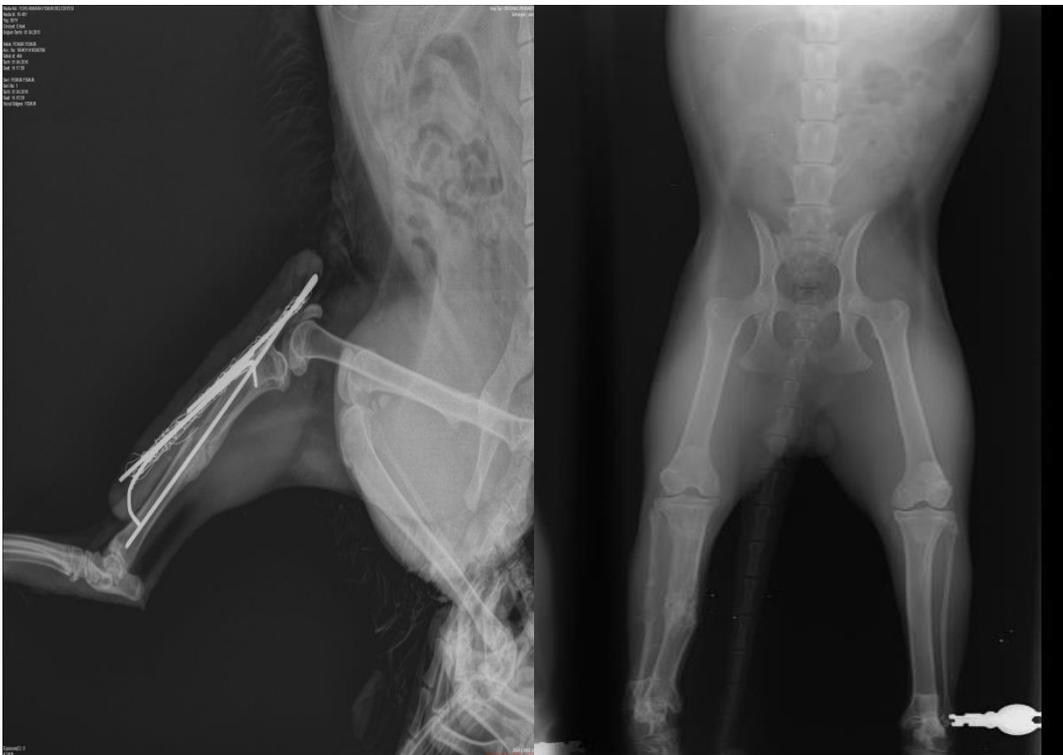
Radiographic appearance of case11 Postoperative 10th day. Figure 2. Same case postoperative 21. days.
